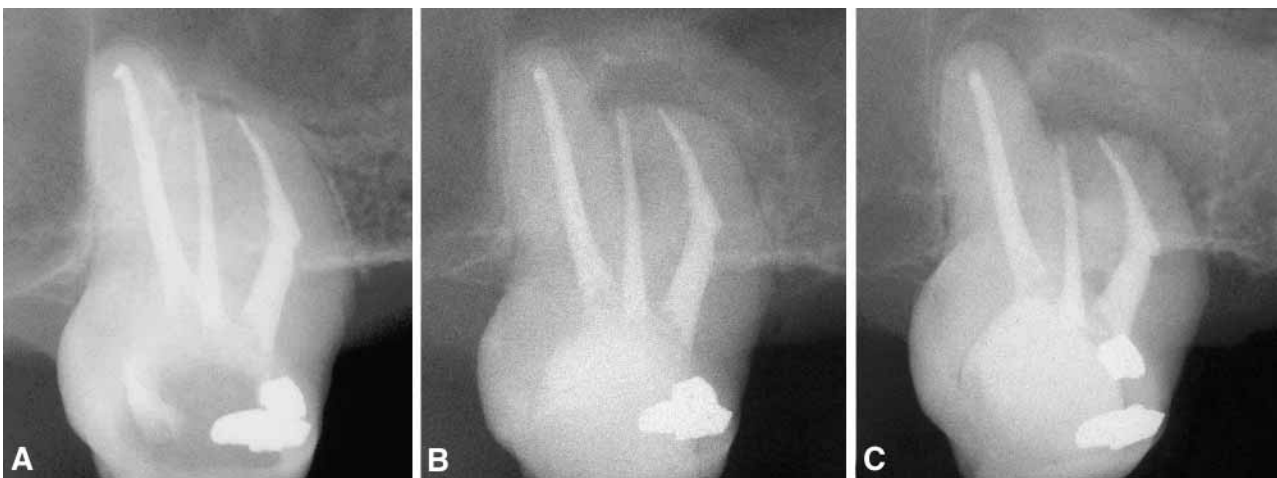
Emerged disease after endodontic treatment. A. Immediate post-operative radiograph of maxillary second molar without evidence of apical periodontitis. B. Emerged disease at 3 years. C. Further expansion of disease at 6 years.
